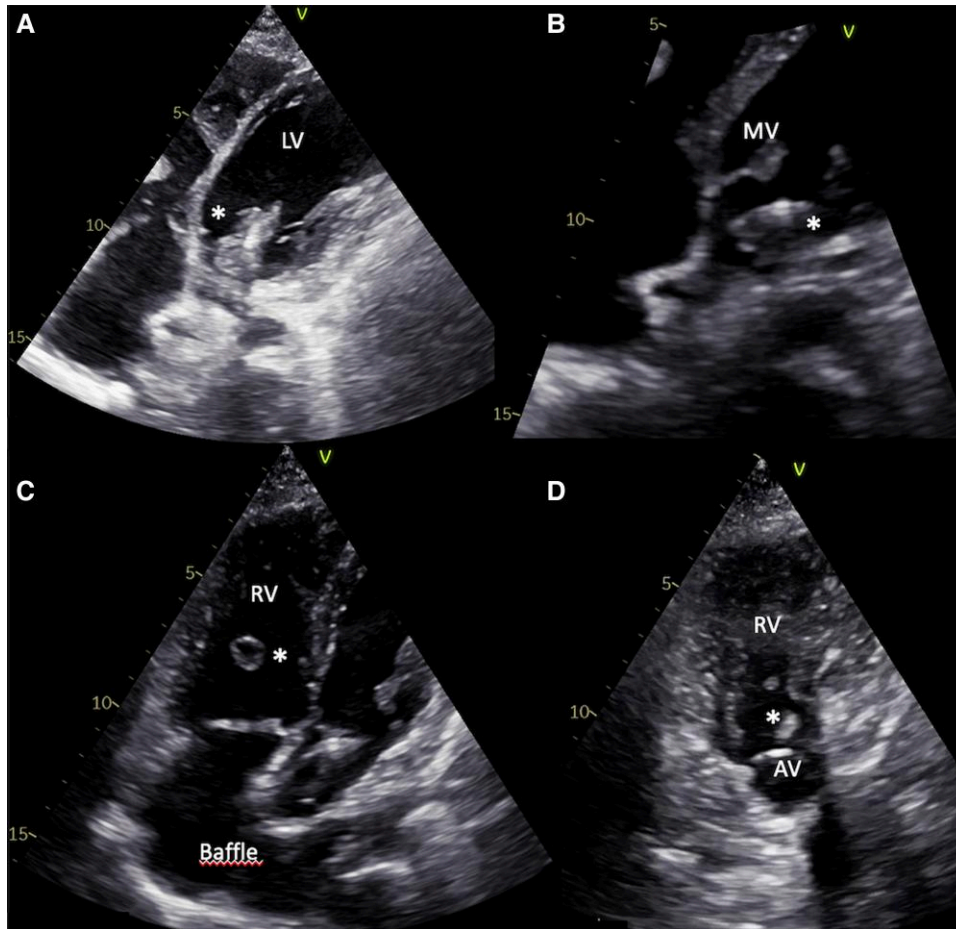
Transthoracic echocardiography demonstrating multiple intracardiac vegetations attached to the pacemaker lead inside the subpulmonary left ventricle (A), with involvement of the mitral valve leaflets (B). A rounded shaped formation with anechoic centre was noted in the systemic left ventricle (C), and a mobile mass was revealed in the right ventricular outflow tract, below the aortic valve (D). AV, aortic valve; MV, mitral valve; LV, left ventricle; RV, right ventricle; asterisks, vegetations/abscess.
